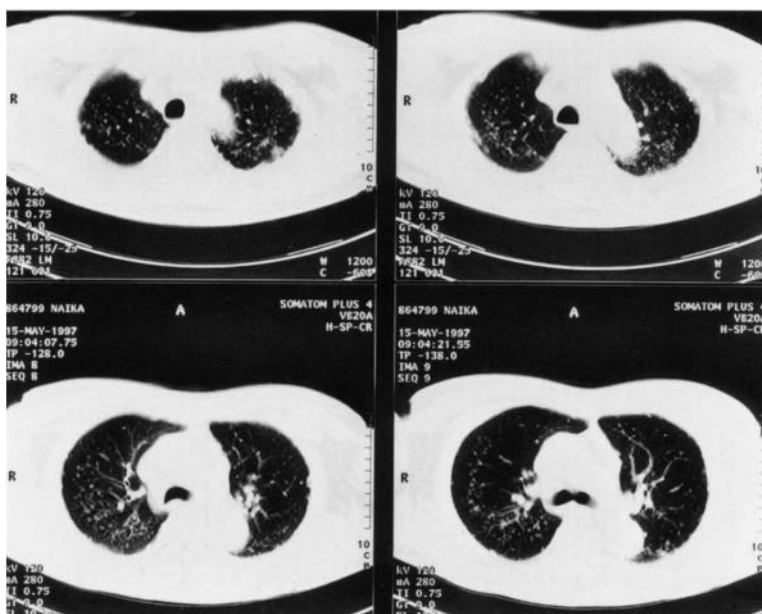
Spiral CT scans obtained with 10-mm collimation demonstrate well-defined nodules in all lung zones with slight predominance in the upper lobes
